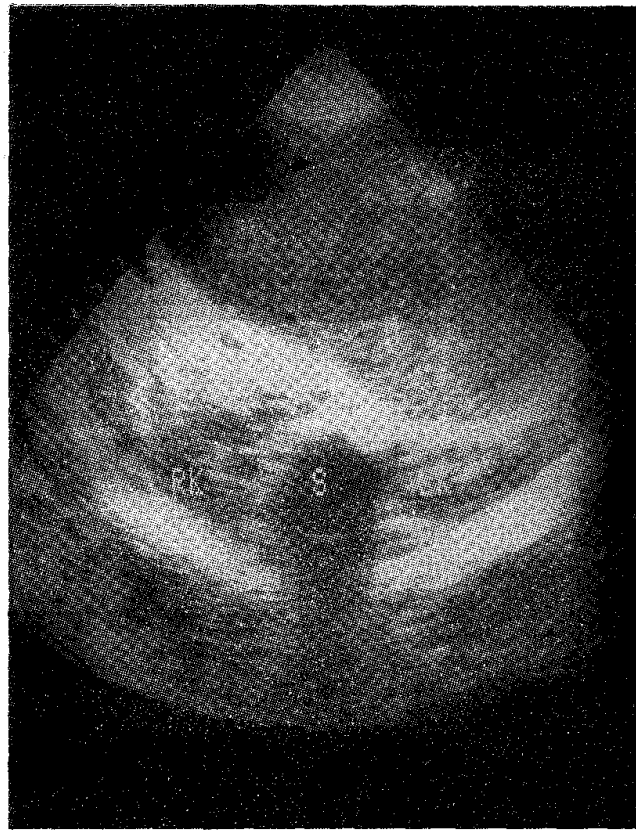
Ultrasound abdomen, transverse scan showing a large cystic mass: Pseudocyst of pancreas - M, Right Kidney - RK, Left Kidney - LK, Spine - S, Liver - Liv.
